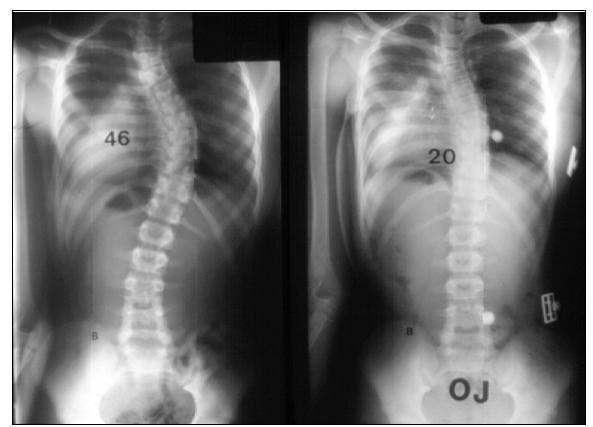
Follow-up roentgenogram of patient without brace (left) and with brace on (right).
